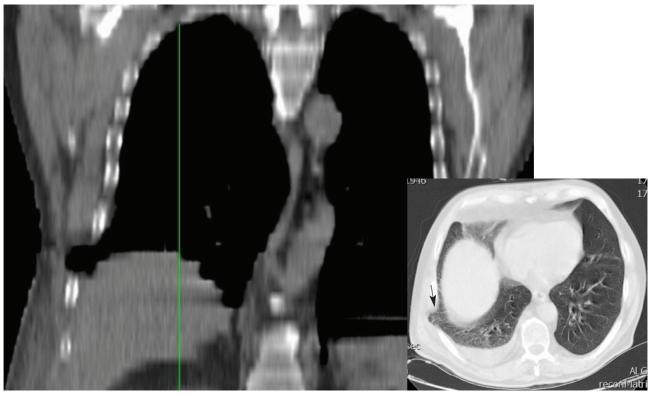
CT scan showing herniated lung wall in coronal and transverse slices (bottom right), in the intercostal space between the 8th and 9th ribs (arrow).
